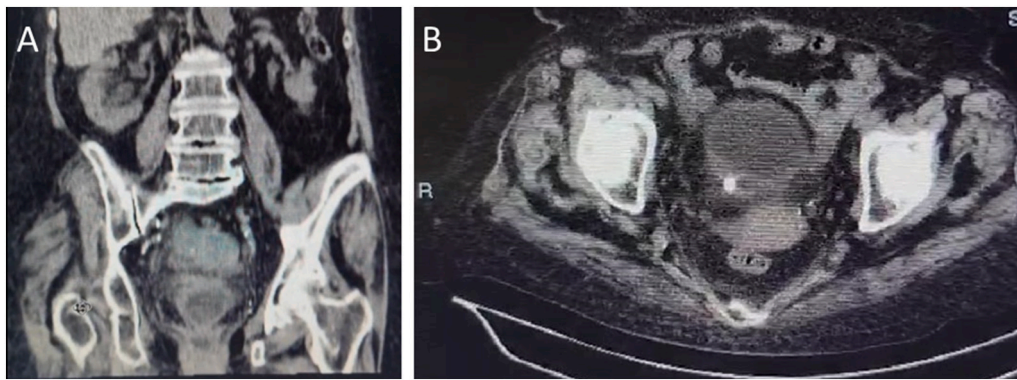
Non contrasted urinary CT scan showing the tip of the catheter in right vesico-ureteric junction with hydronephrosis of the right kidney.
